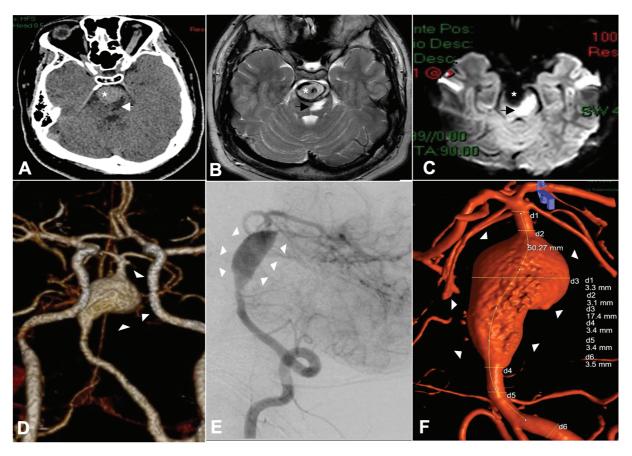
(A) Admission cranial computed tomography scan demonstrating hypodensity in left base of the pons (white arrow) and a well-defined hyperdensity in prepontine cisternal (white asterisk); (B and C) Brain magnetic resonance imaging scan showing hyperdensity in T2 and diffusion-weighted imaging protocols at the level of the left pons (black arrows), and thrombosed basilar artery aneurysm (asterisk); (D) Cerebral tomography angiography showing a giant aneurysm of the basilar artery trunk (white head arrows); (E and F) Angiography in lateral view and three-dimensional reconstruction showing a giant 17 × 29mm basilar trunk aneurysm. No aneurysmal branches were detected (white arrowheads).
